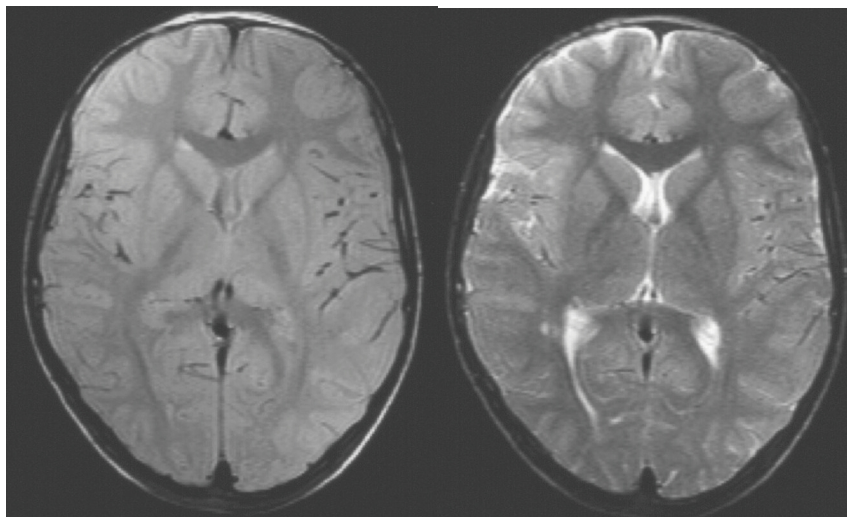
cMRI of proband D.B. Note the lesion in the white matter, right of the trigonum with slight enlargement of the trigonum proximate to the lesion. The lesion is hypointense in the T1-weighted image (left) and hyperintense in the T2-weighted image (right).
